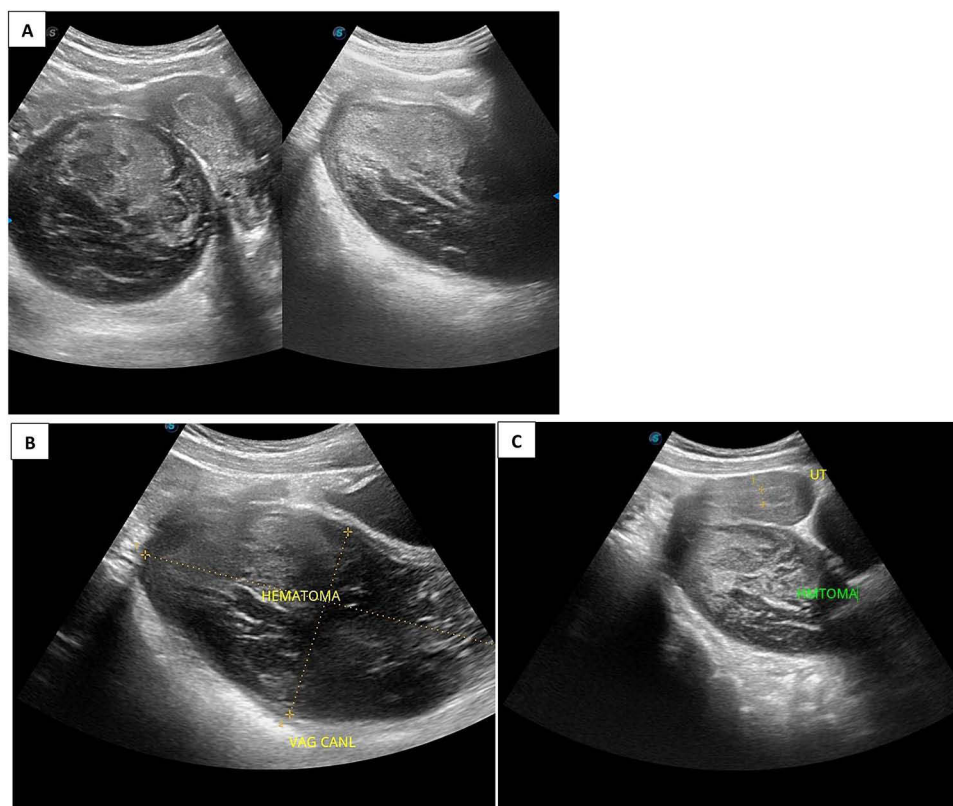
Transabdominal pelvic ultrasound showing (A) a large heterogeneous cystic vaginal mass posterior to the urinary bladder with internal low-level reticular echoes (“fish-net” appearance), (B) the distended vaginal collection measuring 134.5×69.8 mm, and (C) an anteverted uterus (UT) with endometrial thickening (7–8 mm) and a heterogeneous collection inferior to the uterus.
